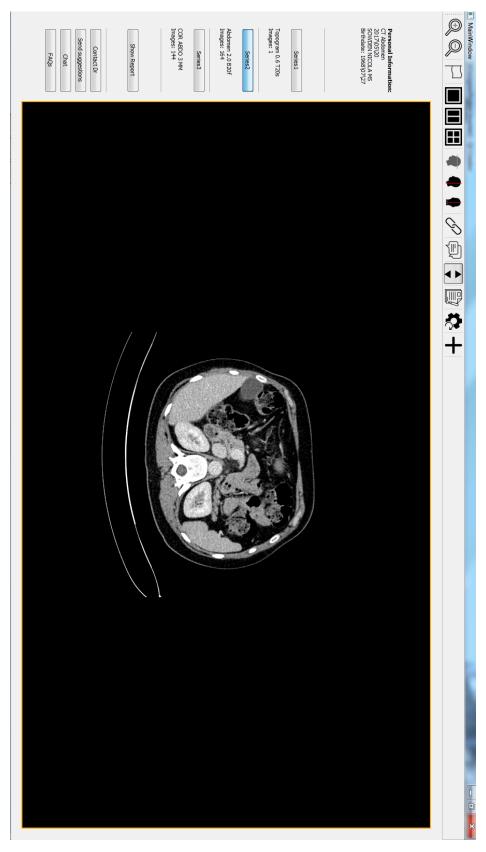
Main Window Displaying CT Abdomen
